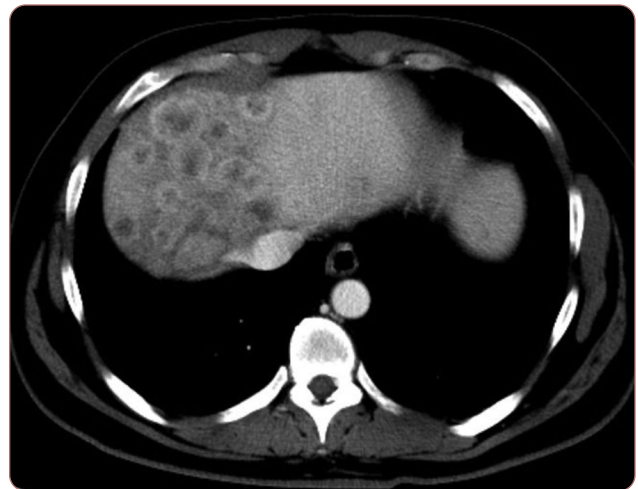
CT of the chest, abdomen, and pelvis.
